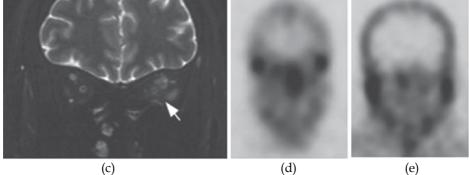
A 44-year-old male with pulmonary sarcoidosis, left eye pain and sixth nerve palsy. (a) Axial T1-weighted image shows a low signal intensity lesion in the left orbital apex (arrow). (b) Gadolinium-enhanced fat suppressed T1-weighted image shows enhancement of the previously seen lesion (arrow). Slight enlargement of the left lacrimal gland is noted (arrowhead). (c) Coronal fat suppressed T2-weighted image shows diffuse increased signal intensity with in the left intraconal fat, representing an inflammatory process (arrow). (d) and (e) ⁶⁷Gallium SPECT images show increased radiopharmaceutical activity in the lacrimal and parotid glands respectively.
